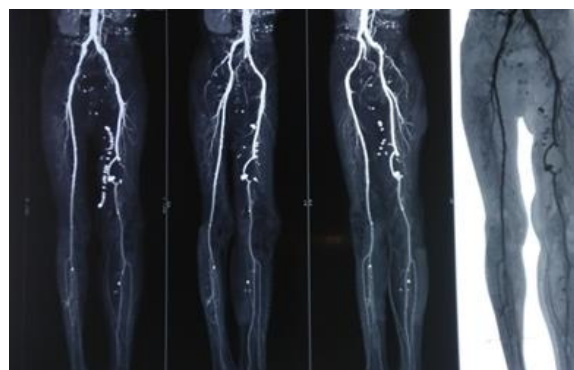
CT angiogram after pseudoaneurysm excision with left great saphenous vein interposition grafting.
